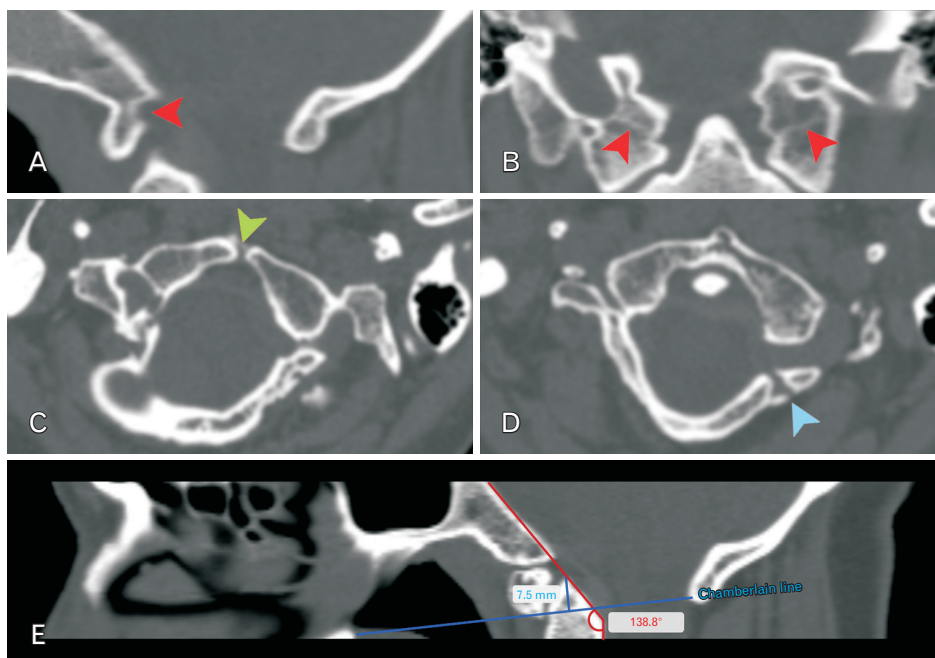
Sagittal (A), coronal (B), axial (C, D) computed tomography scans showing the presence of atlas assimilation (red arrowheads), anterior atlas arch defect (green arrowhead) and posterior arch defect (blue arrowhead). Sagittal image (E) shows the distance between the odontoid apex and Chamberlain's line, lining between the hard palate and the opisthion (7.5 mm), suggesting basilar invagination into the posterior cranial cavity of skull. The angle between clivus and posterior aspect of odontoid process was 138.8°, indicating predisposition to anterior spinal cord compression.
